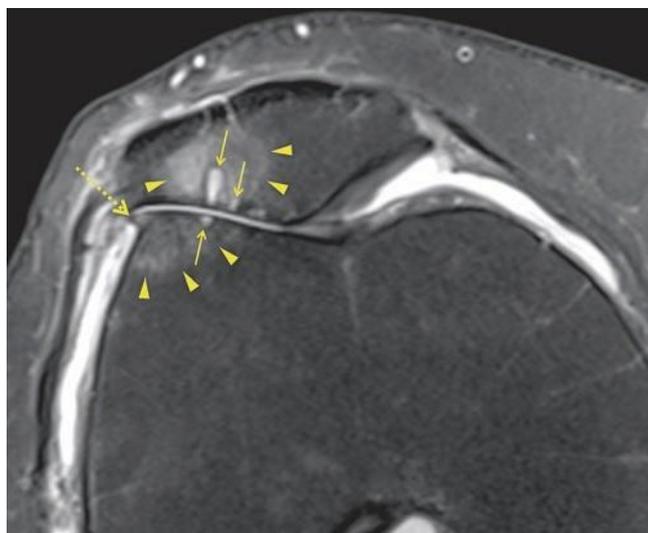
Patellofemoral osteoarthritis. Axial intermediate weighted MRI with fat suppression. There is full-thickness cartilage loss on both sides of the lateral patellofemoral joint associated with subchondral bone marrow lesions, showing an edema pattern (arrowheads) surrounding subchondral cyst-like lesions (arrows). A small osteophyte is also seen (dotted arrow)
